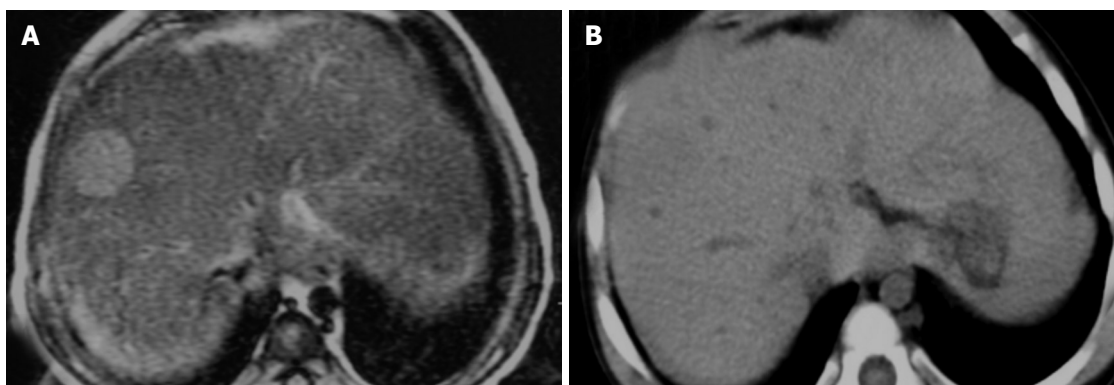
A 16-month-old BA girl with a 2.1 cm MRN in segment 8. A: During pre-enhanced phase of the CT, no nodule can be seen; B: The signal intensity is hyperintense on T2WI MRI.
